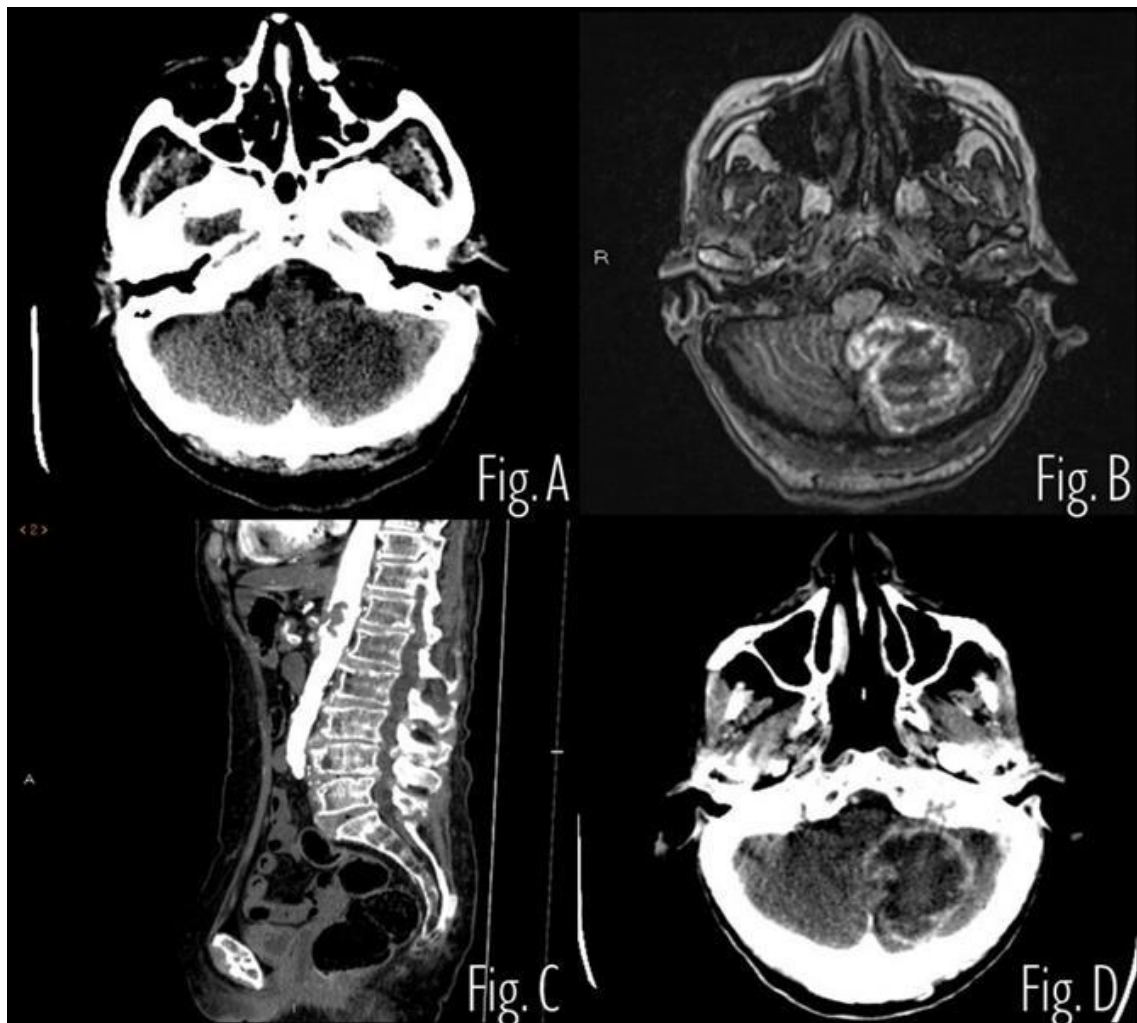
Non-enhanced head CT: Left cerebellar hemisphere hypodensity with subtle mass effect over the 4th ventricle. Fig B: Brain MRI: non-enhanced volumetric T1 sequence. Subacute intraparenchymal Left cerebellar hemisphere hemorrhage compatible with hemorrhagic transformation of ischemic infarct and associated mass effect over the 4th ventricle caused triventricular hydrocephalus. Fig C: Abdominal angio CT: intraluminal floating thrombus of 3cm in the abdominal aorta compatible with a thrombus located at the origin of the celiac trunk and the superior mesenteric artery Fig D: Non-enhanced head CT which shows no significant interval change in size and appearances of the left cerebellar haemorrhagic stroke with peripheral ring enhancement.
